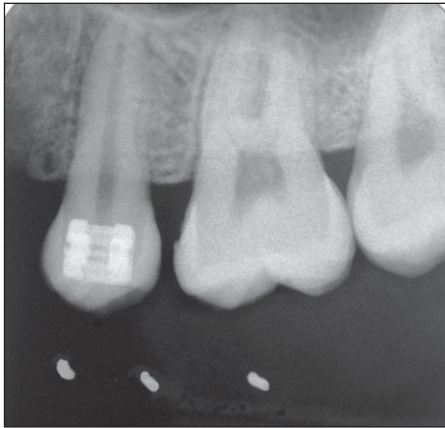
On the resultant radiograph the three dots represent the images of three metal orthodontic wires on the radiographic template.
